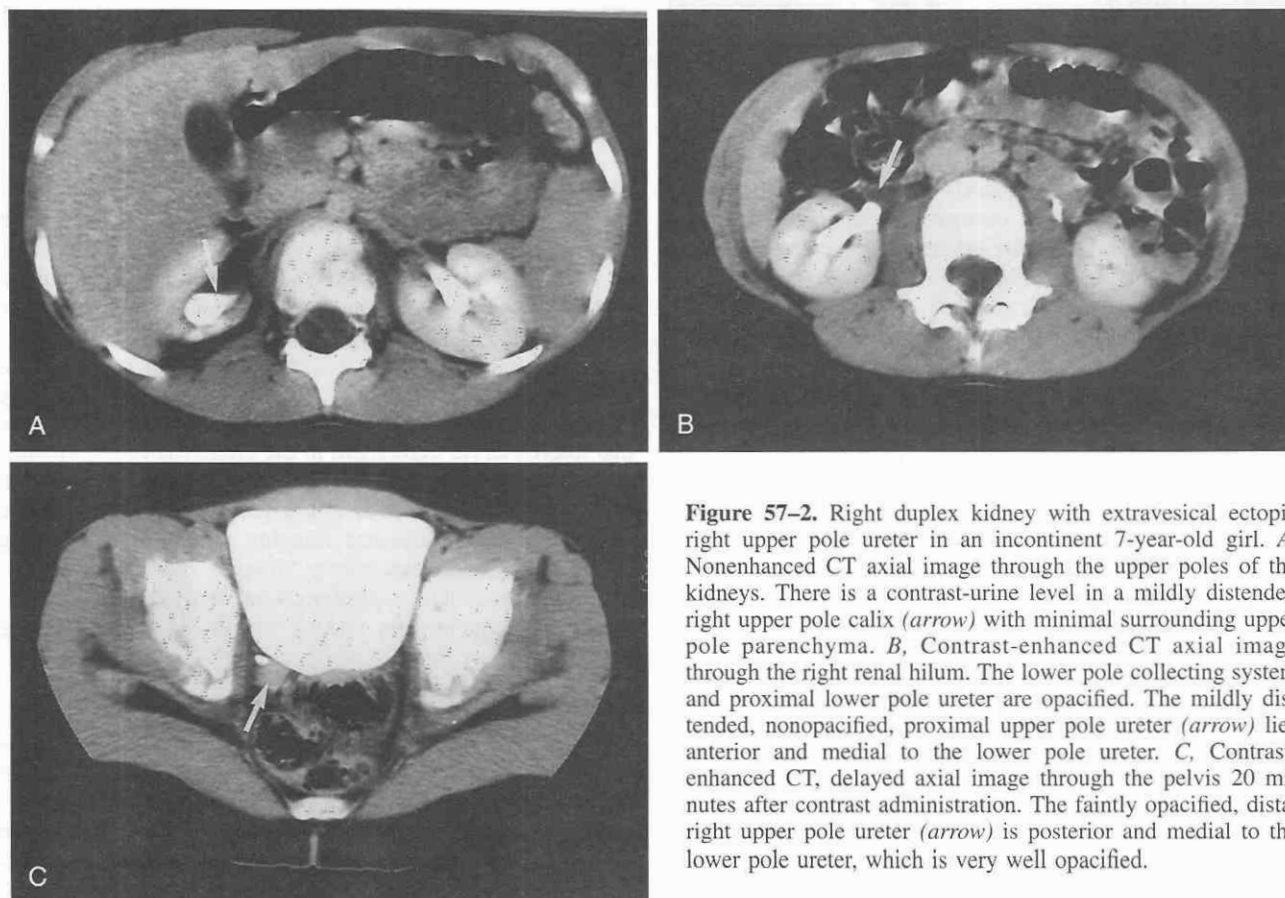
Right duplex kidney with extravesical ectopic right upper pole ureter in an incontinent 7-year-old girl. *A*, Nonenhanced CT axial image through the upper poles of the kidneys. There is a contrast-urine level in a mildly distended right upper pole calyx (arrow) with minimal surrounding upper pole parenchyma. *B*, Contrast-enhanced CT axial image through the right renal hilum. The lower pole collecting system and proximal lower pole ureter are opacified. The mildly distended, nonopacified, proximal upper pole ureter (arrow) lies anterior and medial to the lower pole ureter. *C*, Contrast-enhanced CT, delayed axial image through the pelvis 20 minutes after contrast administration. The faintly opacified, distal right upper pole ureter (arrow) is posterior and medial to the lower pole ureter, which is very well opacified.
